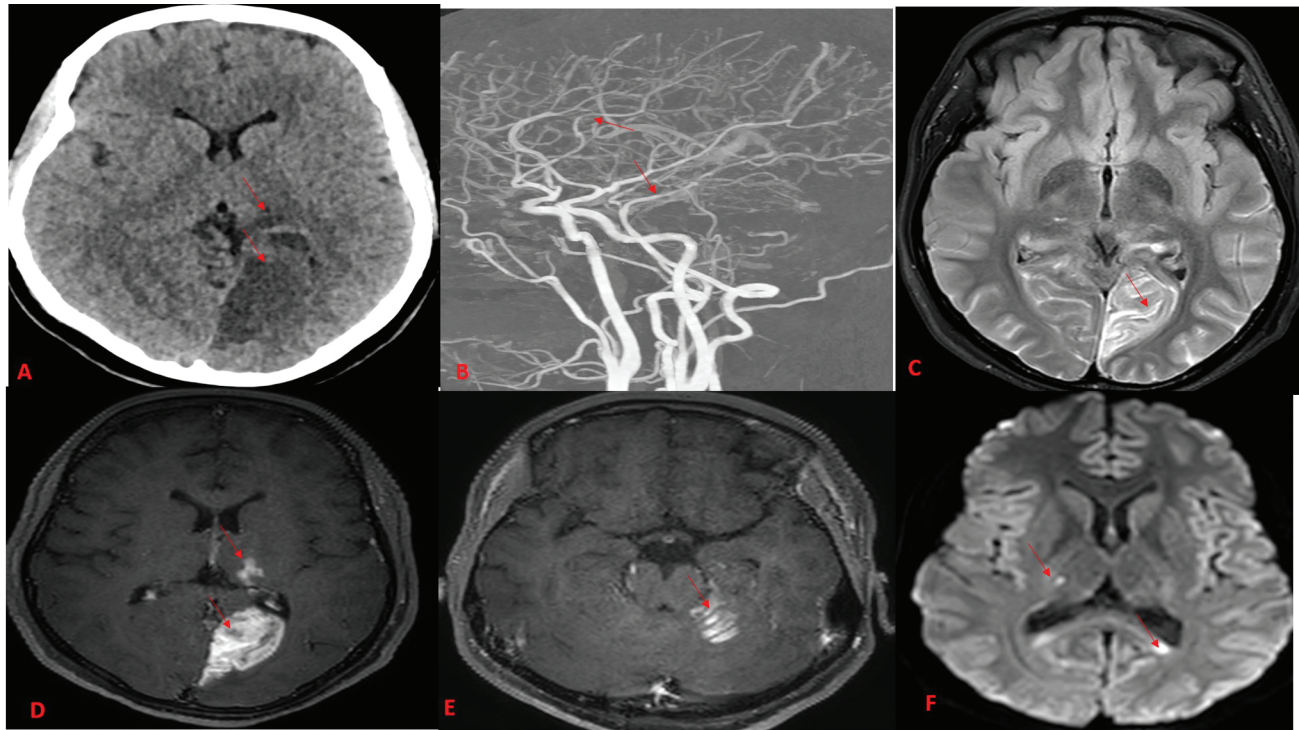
A 22-year-old girl presented in emergency with a clinically posterior circulation stroke on 31.10.2020. Noncontrast computed tomography (A) showing hypodensity in the left occipital lobe and left thalamus (arrow). Computed tomography angiography maximum intensity projection image (B) showing a long-segment beading appearance in bilateral posterior cerebral artery, distal basilar artery (arrow), and distal branches of middle cerebral artery. Magnetic resonance imaging brain done 10 days later reveals fluid-attenuated inversion recovery (C) hyperintensity in the left occipital lobe (arrow) with T1 + C images (D, E) showing contrast enhancement (in the left occipital lobe, thalamus, and left lateral cerebellum (arrow) s/o subacute infarct. No abnormal vessel wall enhancement was seen. Diffusion-weighted imaging (F) showing restriction foci noted in bilateral splenium and right thalamus (arrow) s/o acute infarct.
